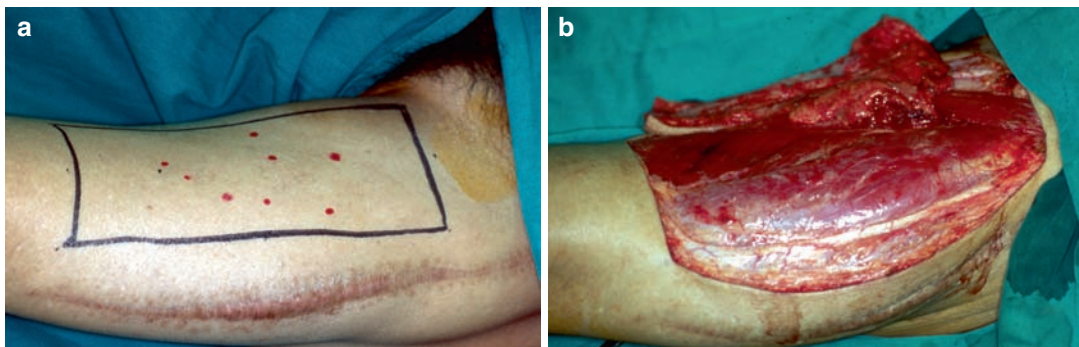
(a) Multiple arterial signals have been mapped by handheld Doppler over the anteromedial thigh in preparation for a free style flap harvest. Note the scar from the previous use of an anterolateral thigh flap. (b) A fasciocutaneous flap has been harvested in a free style manner based on the most proximal arterial Doppler signal to increase distal flap reach.
